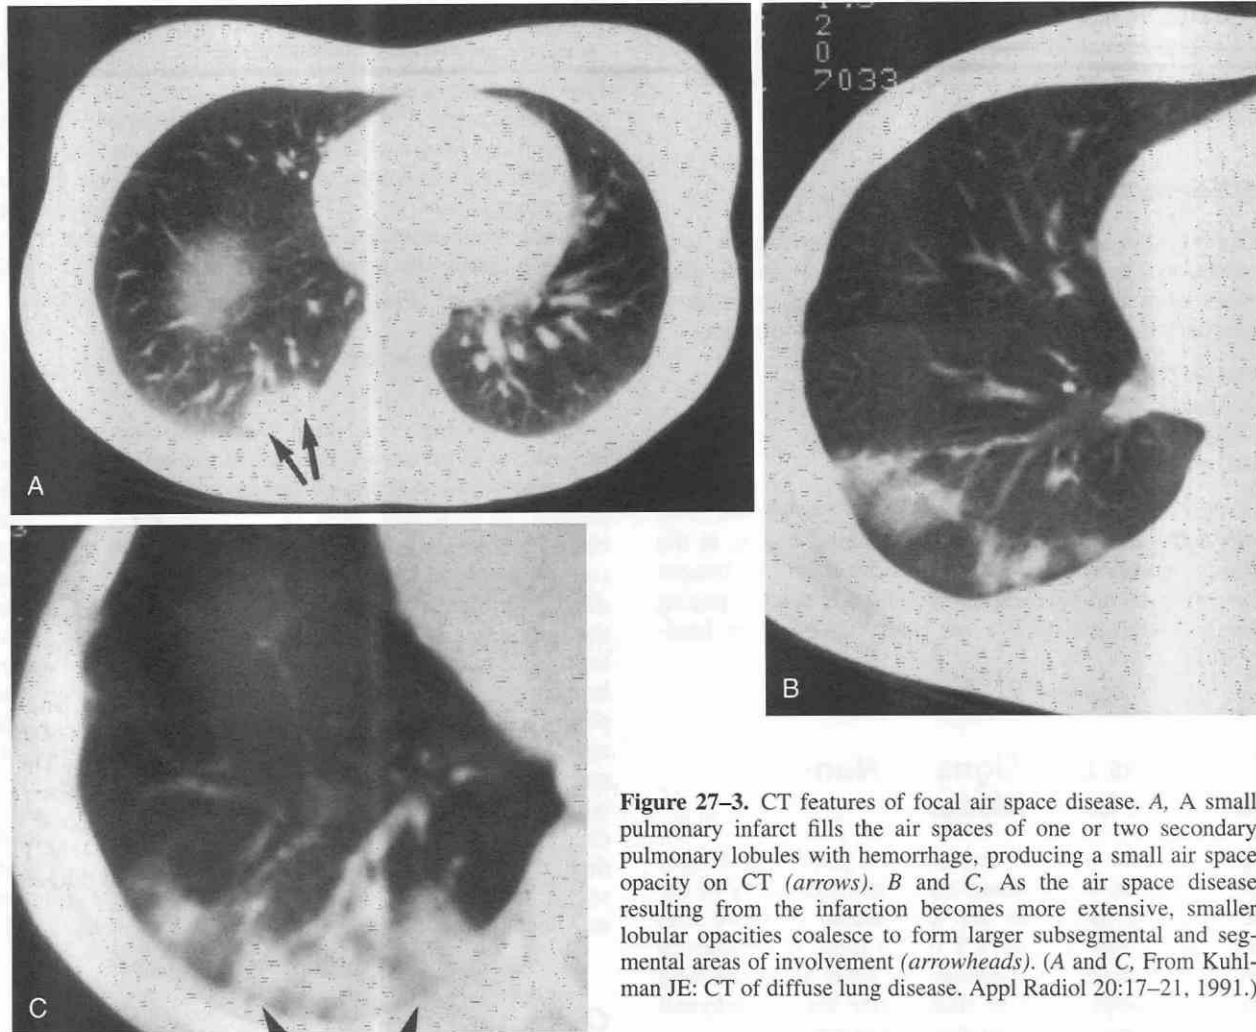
CT features of focal air space disease. *A*, A small pulmonary infarct fills the air spaces of one or two secondary pulmonary lobules with hemorrhage, producing a small air space opacity on CT (arrows). *B* and *C*, As the air space disease resulting from the infarction becomes more extensive, smaller lobular opacities coalesce to form larger subsegmental and segmental areas of involvement (arrowheads). (*A* and *C*, From Kuhlman JE: CT of diffuse lung disease. Appl Radiol 20:17-21, 1991.)
